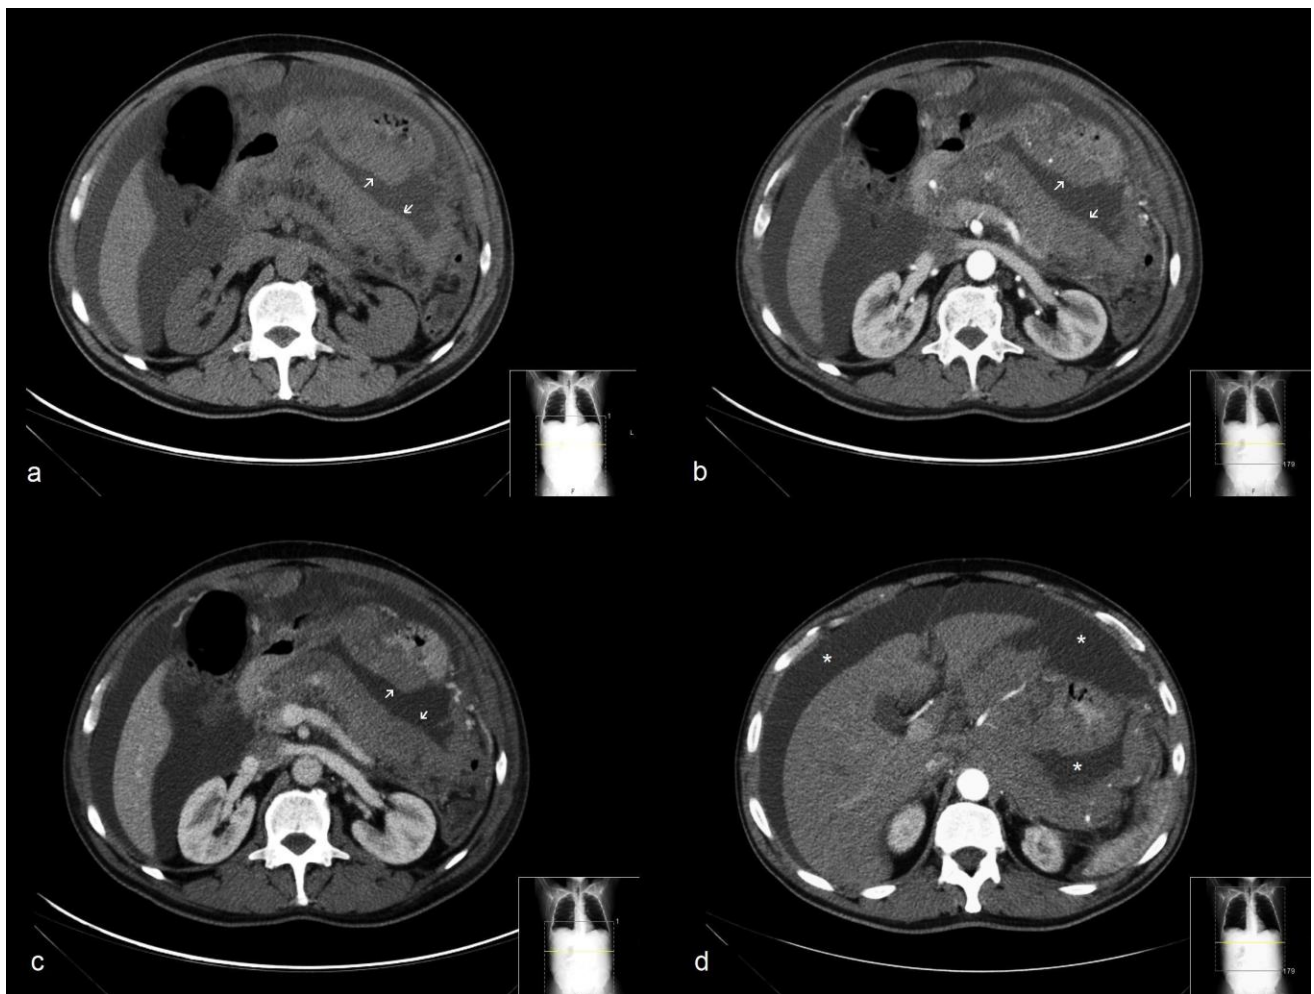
Sixty-one-year-old male with Burkitt lymphoma. Plain and contrast enhanced CT of the abdomen (Scanner: Multidetector CT Philips Brilliance 16- slices®. Protocol: 250mAs, 120kV, 5mm slice thickness, 100ml iobitridol Xenetix® (350 mg Iodine/ml)). a) Axial plain CT shows diffuse nodular thickening of the peritoneum in the lesser sac (arrows). At the same level, axial contrast enhanced CT in the arterial b) and portal phase c) shows heterogeneous enhancement of the nodular peritoneal thickening (arrows); d) Axial contrast enhanced CT, at a more cranial level, demonstrates low attenuation free peritoneal effusion also filling the lesser sac (asterisk).
